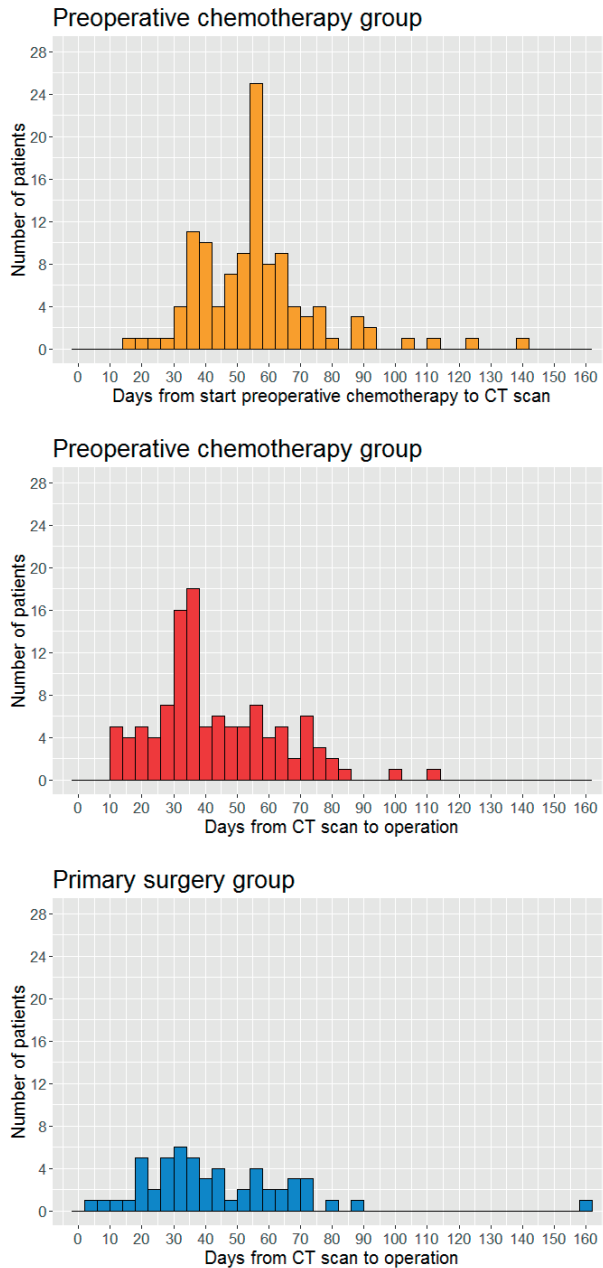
Histograms showing the timing of the CT scans.
